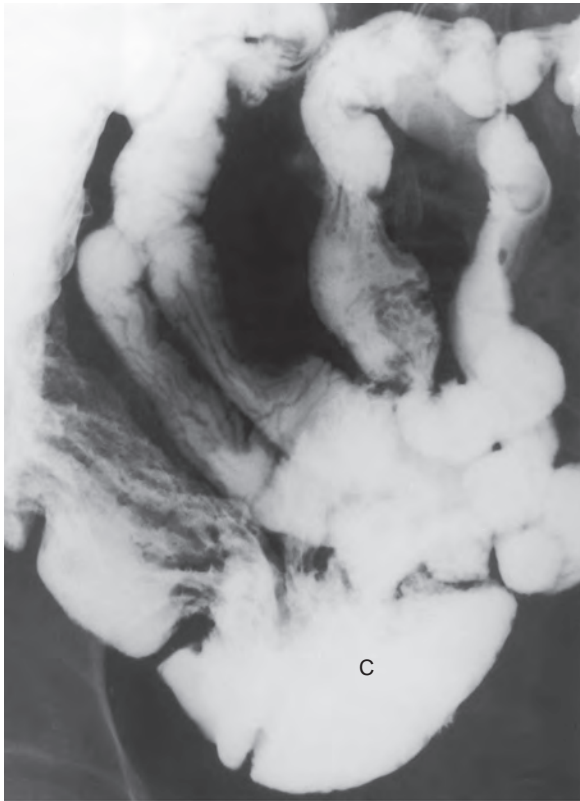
Peroral small bowel follow-through study in a posthysterectomy patient with pelvic small bowel loops lying deep within the pelvis. A prone image of the pelvis with a bolster placed beneath the patient and x-ray tube angulation clearly shows the cecum (C) and ileocecal junction. Note how pelvic loops of ileum are well separated and visualized.
